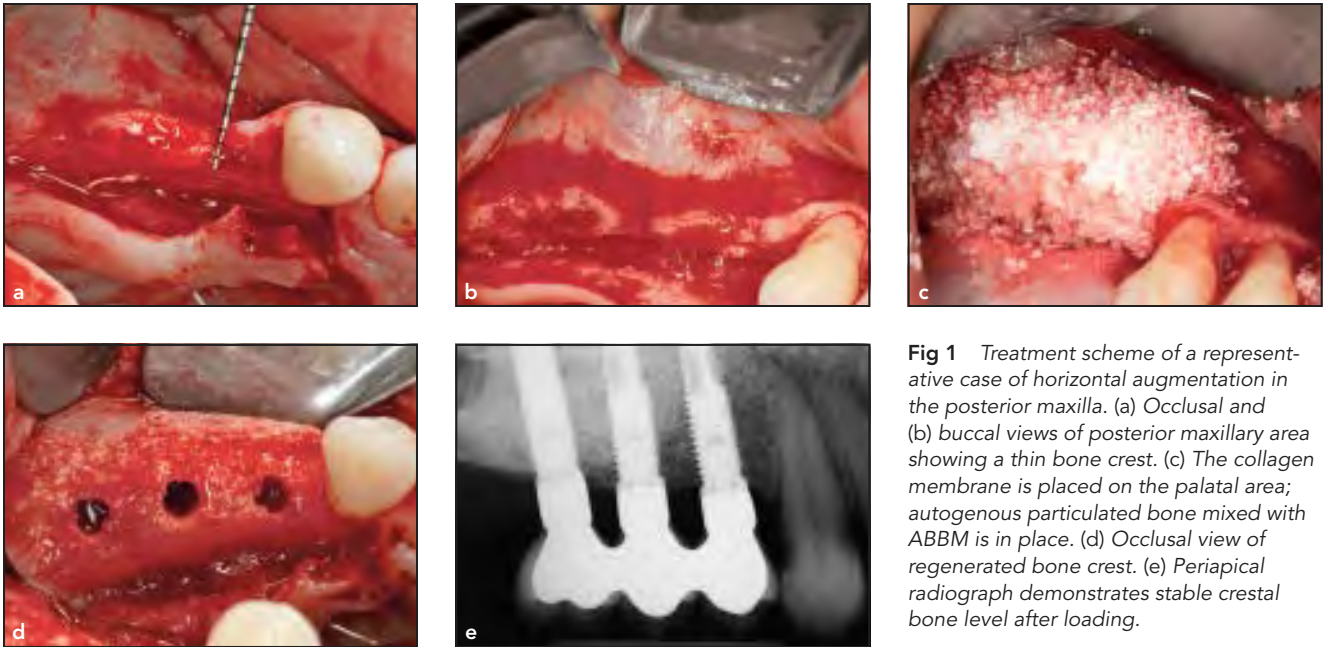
Treatment scheme of a representative case of horizontal augmentation in the posterior maxilla. (a) Occlusal and (b) buccal views of posterior maxillary area showing a thin bone crest. (c) The collagen membrane is placed on the palatal area; autogenous particulated bone mixed with ABBM is in place. (d) Occlusal view of regenerated bone crest. (e) Periapical radiograph demonstrates stable crestal bone level after loading.
